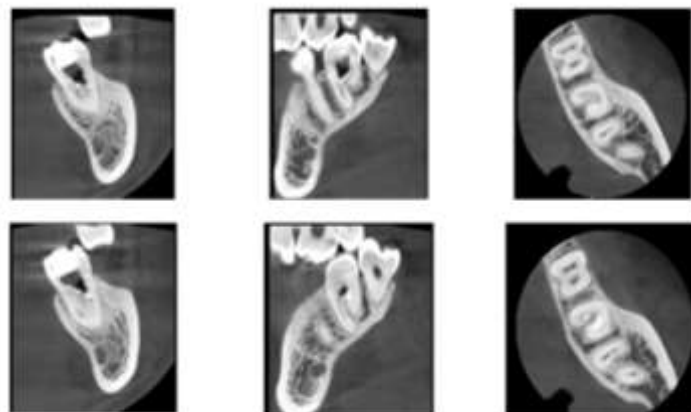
CBCT images for confirmation
